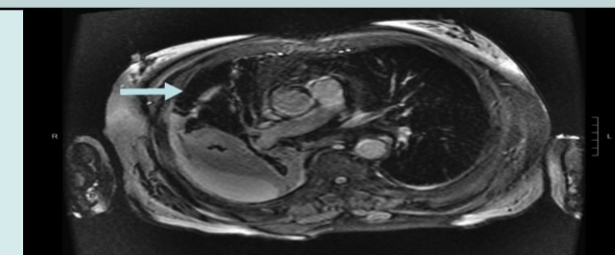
Magnetic Resonance Imaging (MRI) Abdomen with and without IV contrast
